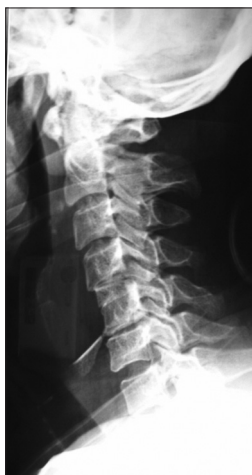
Early postoperative X-ray control of a patient undergoing C4-C5, C5-C6 interbody fusion. The lower graft is totally extruded. This was removed at revision surgery
